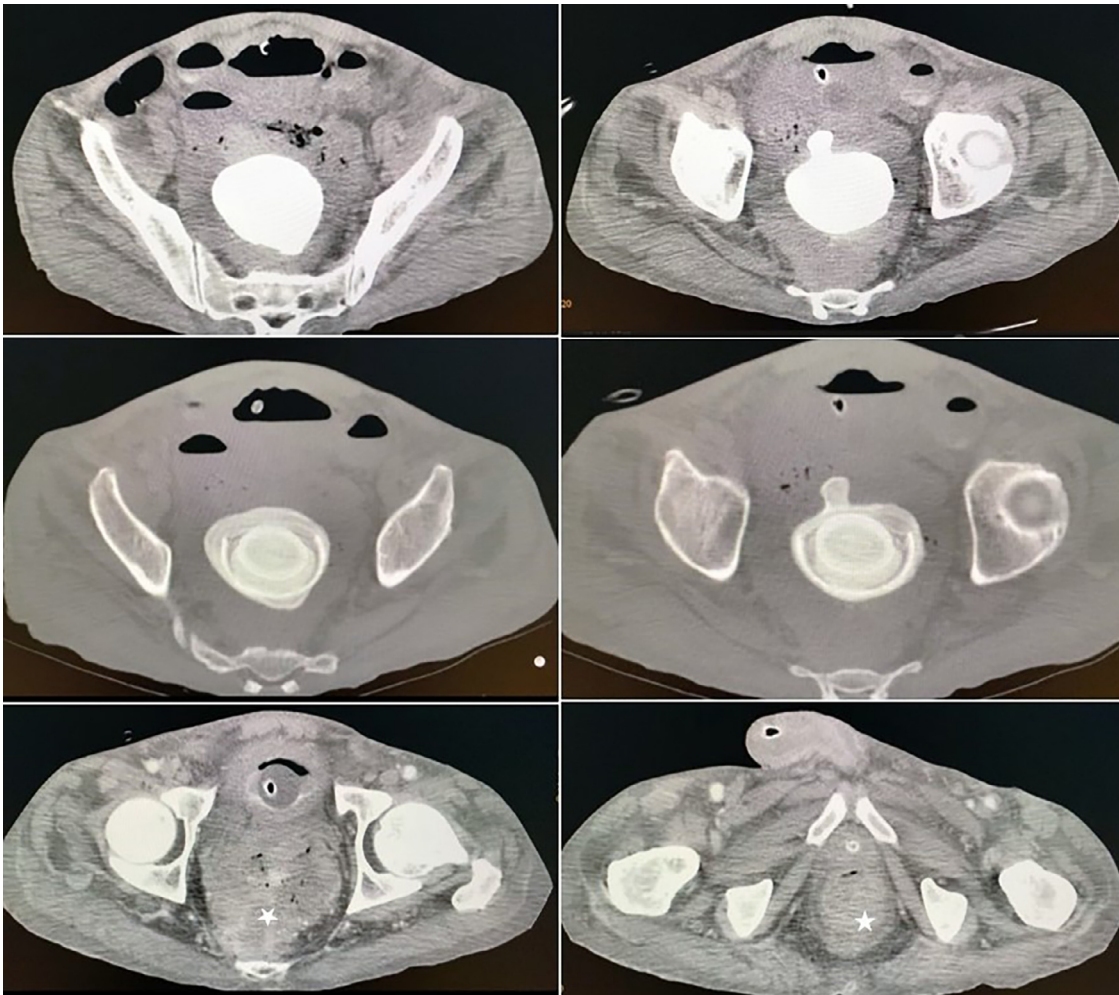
Axial abdominal CT images with contrast injection showing irregular thickening of the upper rectal wall (white star) and the migration of the large stone into the rectum (R).
